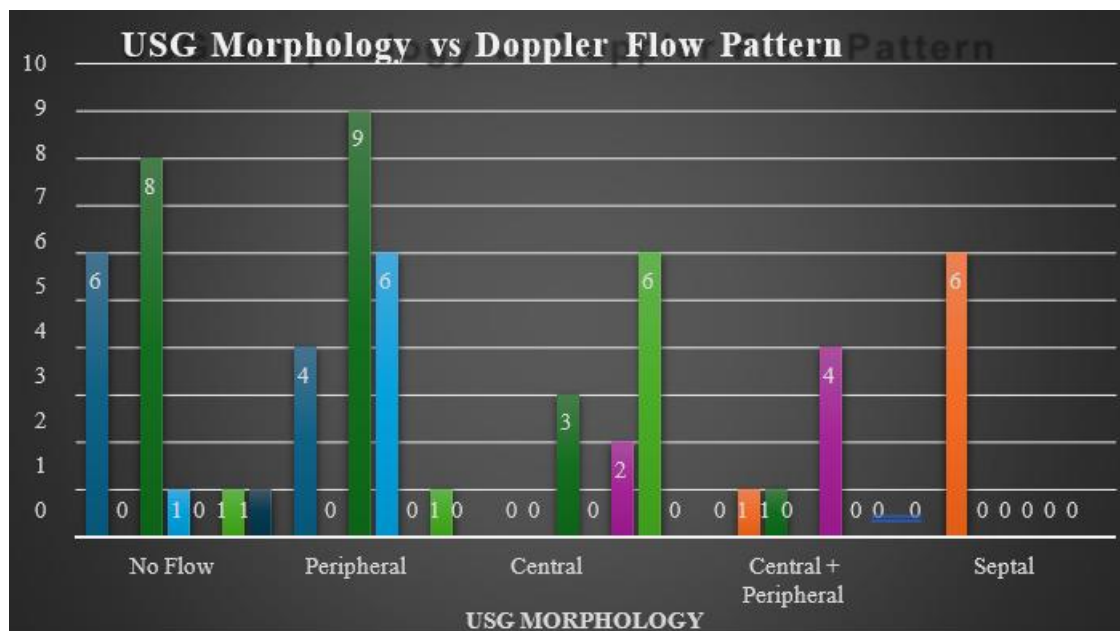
USG Morphology vs Colour Doppler Vascularity Pattern
